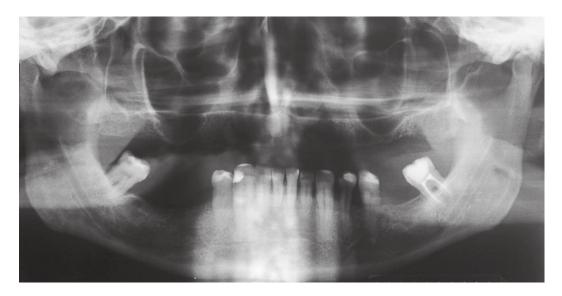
Panoramic radiograph evincing pneumatization of the maxillary sinus on both sides.
